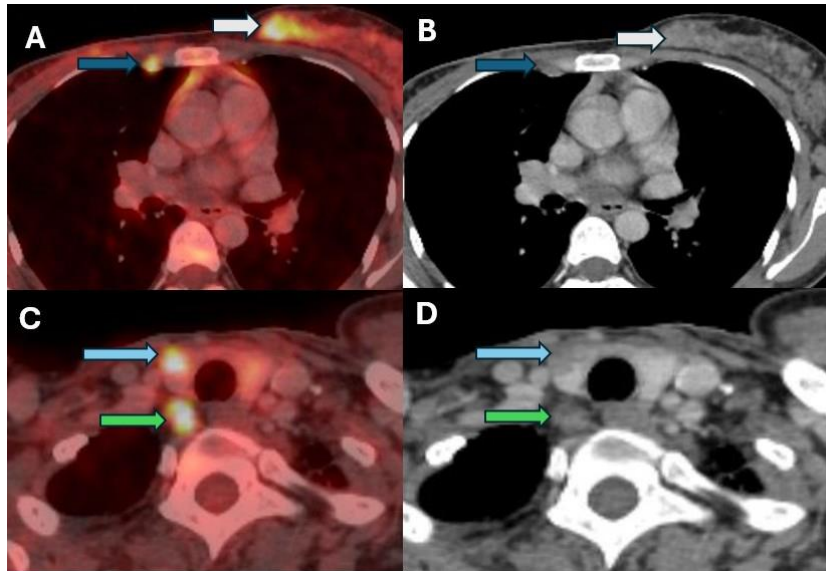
A) Axial PET/CT fused images and B) CT only show FDG avid heterogenous ill-defined soft tissue thickening of glandular tissue at medial aspect of left breast (white arrows) and a right internal mammary lymph node (dark blue arrow). C) Axial PET/CT fused images and D) CT only show FDG avid non enhancing lesion in the right lobe of thyroid (sky blue arrow) and right lower cervical (station 1R)/ infraclavicular lymph node (green arrow)
